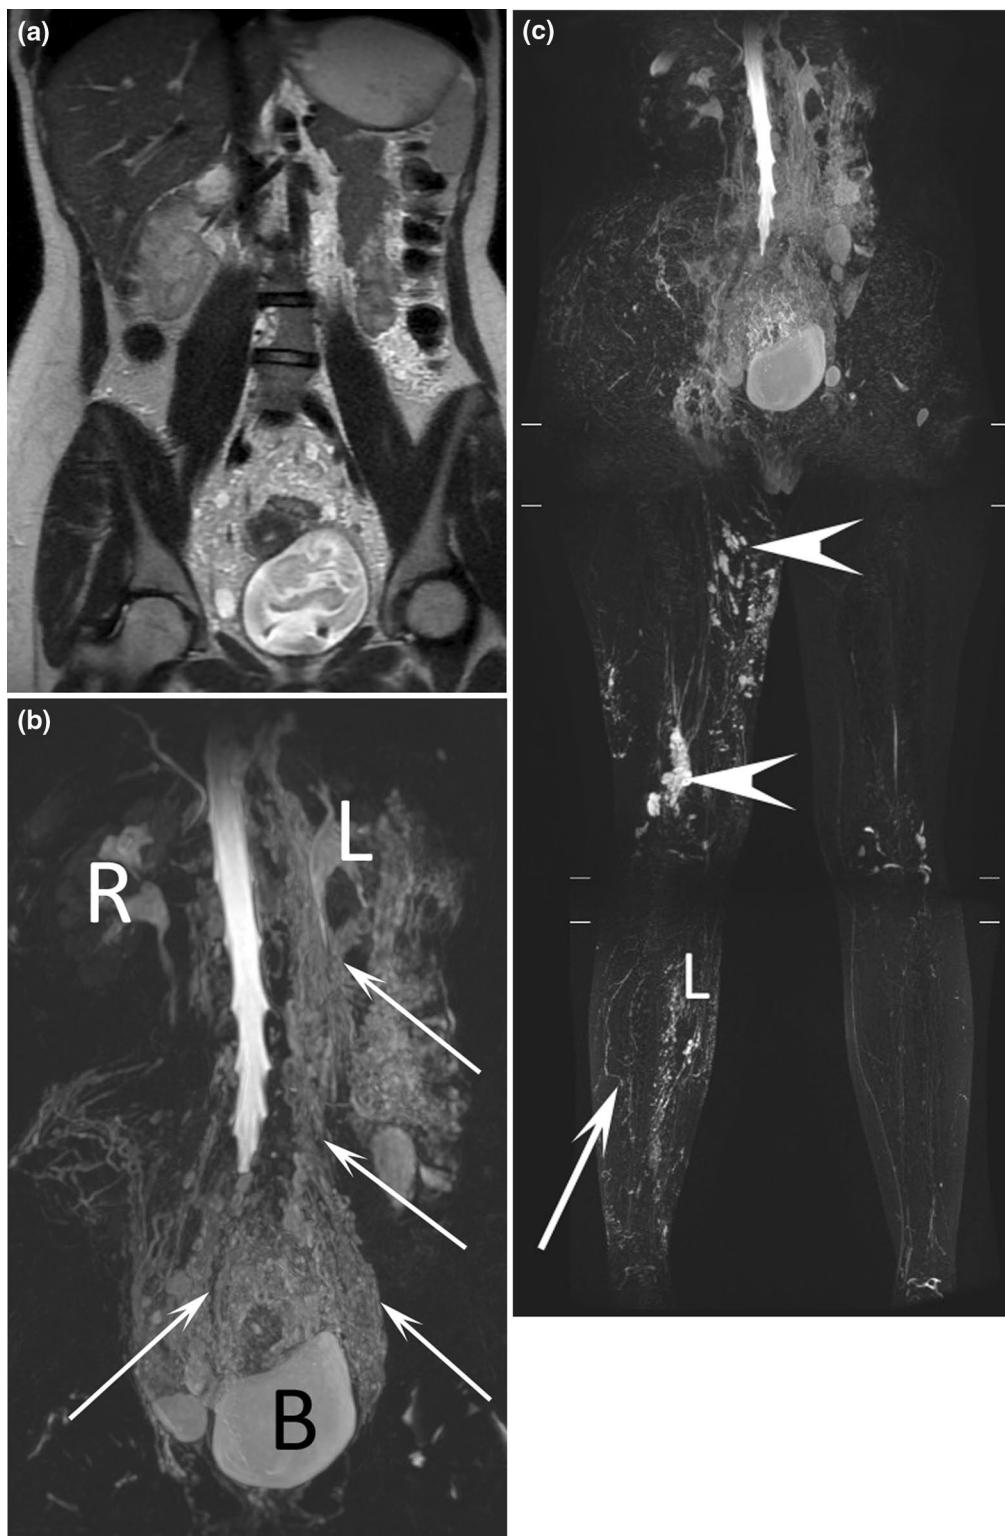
17-year-old female patient with chyluria and vaginal chylous discharge. Coronal T2-weighted MR image a demonstrated abnormal lymphatic vessels in the abdomen, pelvis, and retroperitoneum, which were better seen with (b) coronal MR lymphography with MIP reconstruction. Dilated lymphatic vessels (arrows) close to the bladder, ureters, colon, and uterine cervix were also demonstrated. *R* right kidney, *L* left kidney. This patient also presented with right lower limb lymphedema (*L*) and cystic lymphatic malformations (arrows) on coronal MR lymphography with MIP reconstruction (c)
